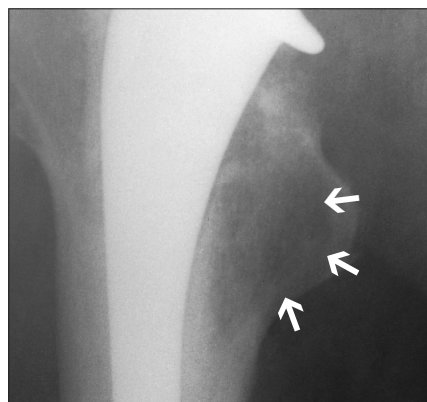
Radiograph showing wear debris.
